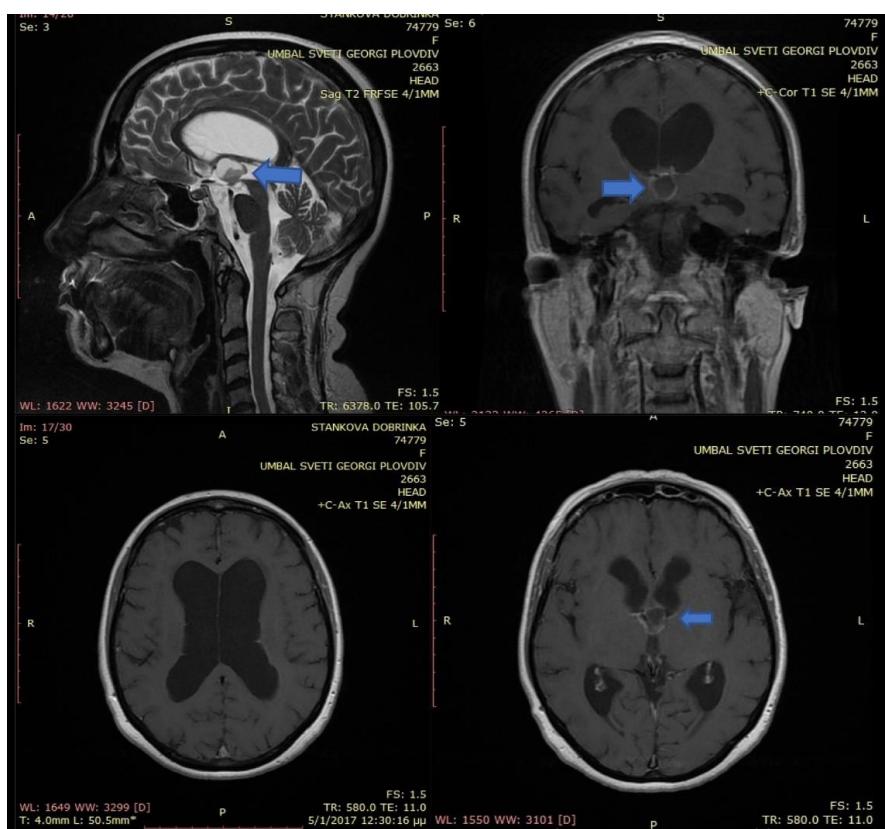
The T2-saggital view of the MRI (left upper image – arrow) presenting a mass closely attached to the roof of the anterior third ventricle; the T1-coronal view presents a well circumscribed formation (right upper image – arrow); the axial MRI (both lower images) showed the cyst obstructing the ventricles and causing obstructive hydrocephalus.
